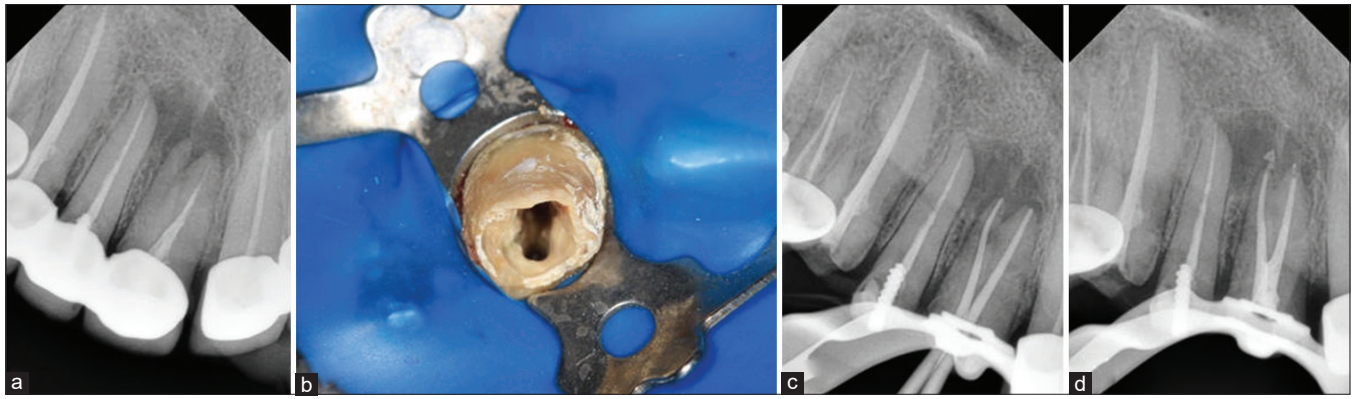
Diagnostic radiograph showing two roots with inadequate root canal treatment and periapical radiolucency (a), access cavity showing two orifices (b), master cone radiograph (c), and obturation (d)
